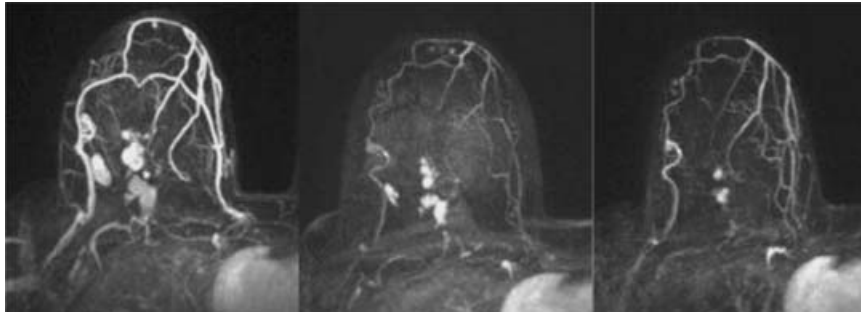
Reinduction treatment series. Breast MRI: maximum intensity projections (MIPs) of contrast-enhanced T1 gradient echo images of the right breast. Left image: baseline prevaccine. Multiple enhancing masses with increased vascularity to the breast; peak enhancement greater than 250% with washout perfusion pattern consistent with neoplasm. Middle image: after inoculation no. 3 (2 months); note the regression of multiple lesions and reduced vascularity; peak enhancement 150%. Right image: After inoculation no. 6 (5 months); note the progressive decrease in size of masses and enhancement; peak enhancement 131%.
